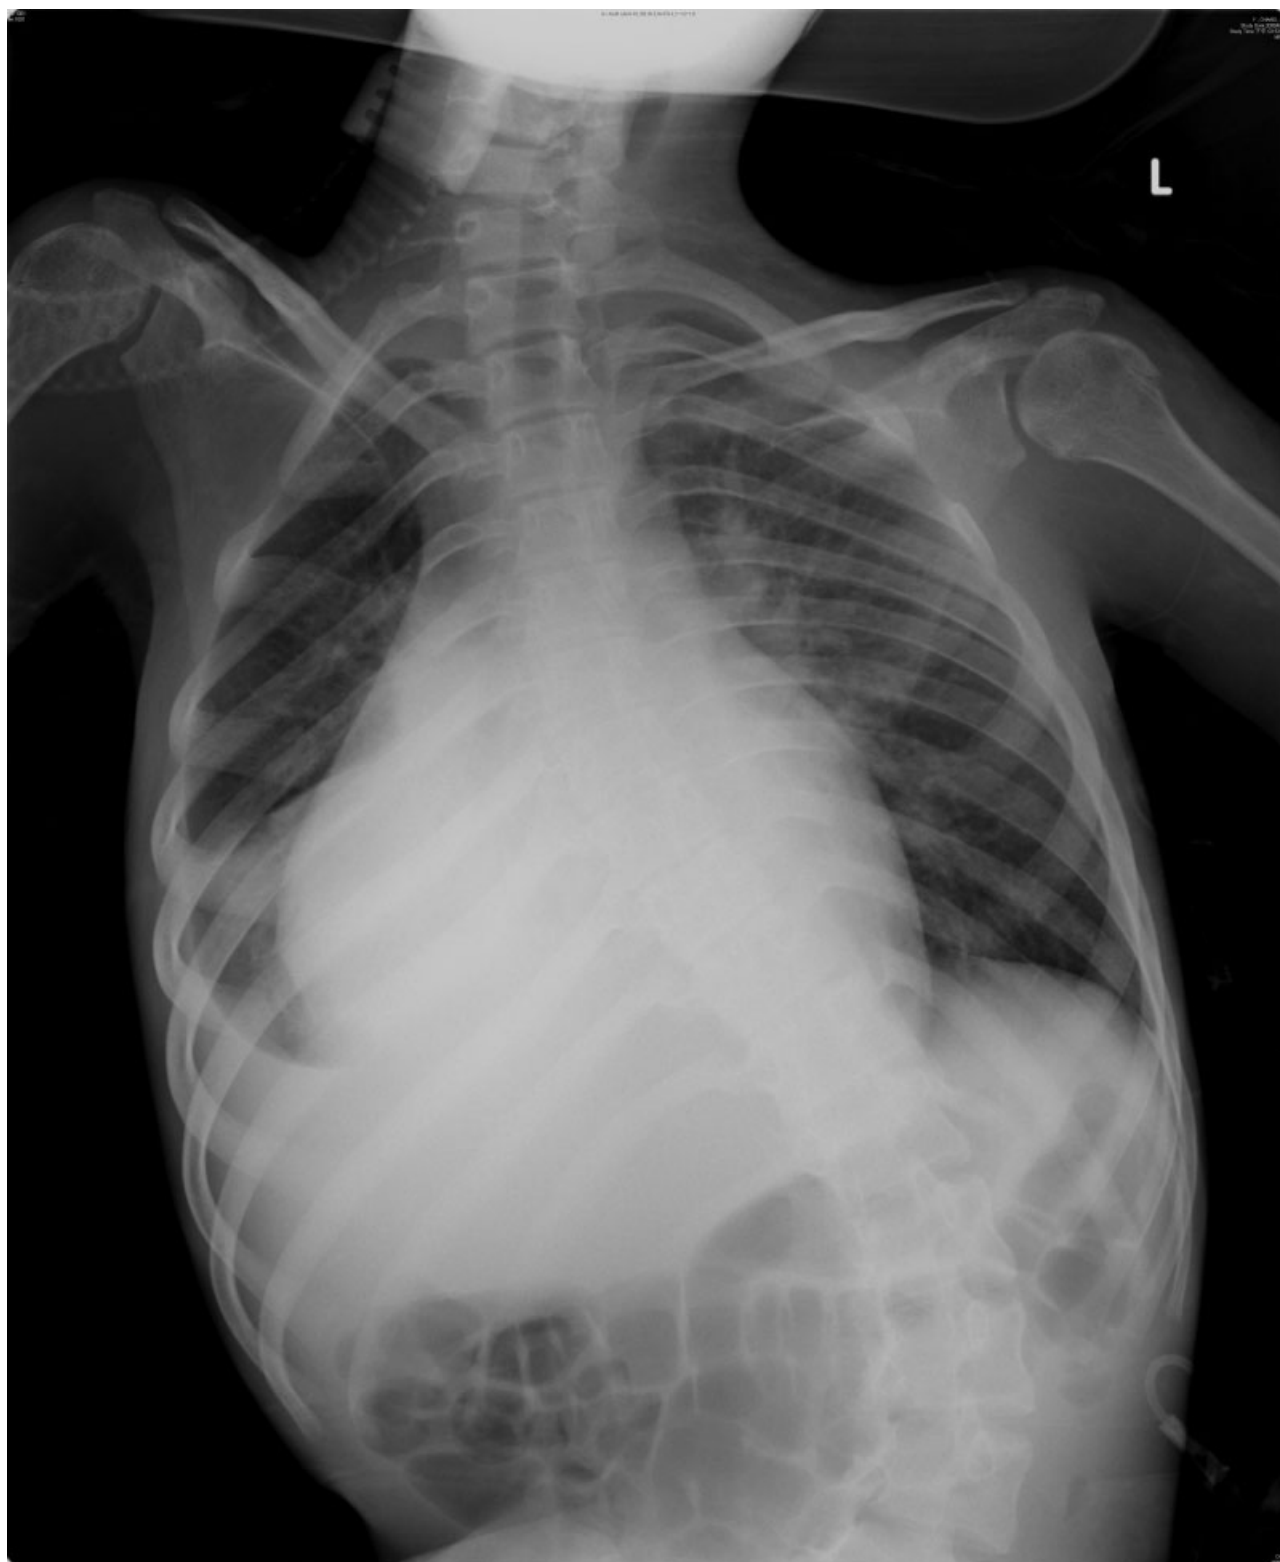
Chest x-ray at admission showed an enlarged cardiac silhouette and right pleural effusion.
